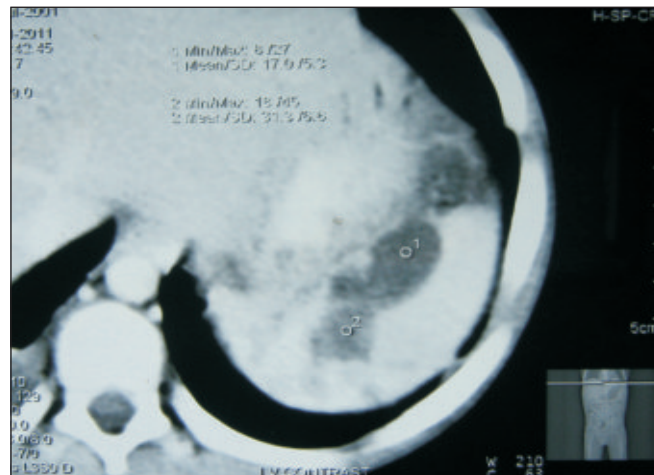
CT Scan Abdomen showing multiple splenic abscess
